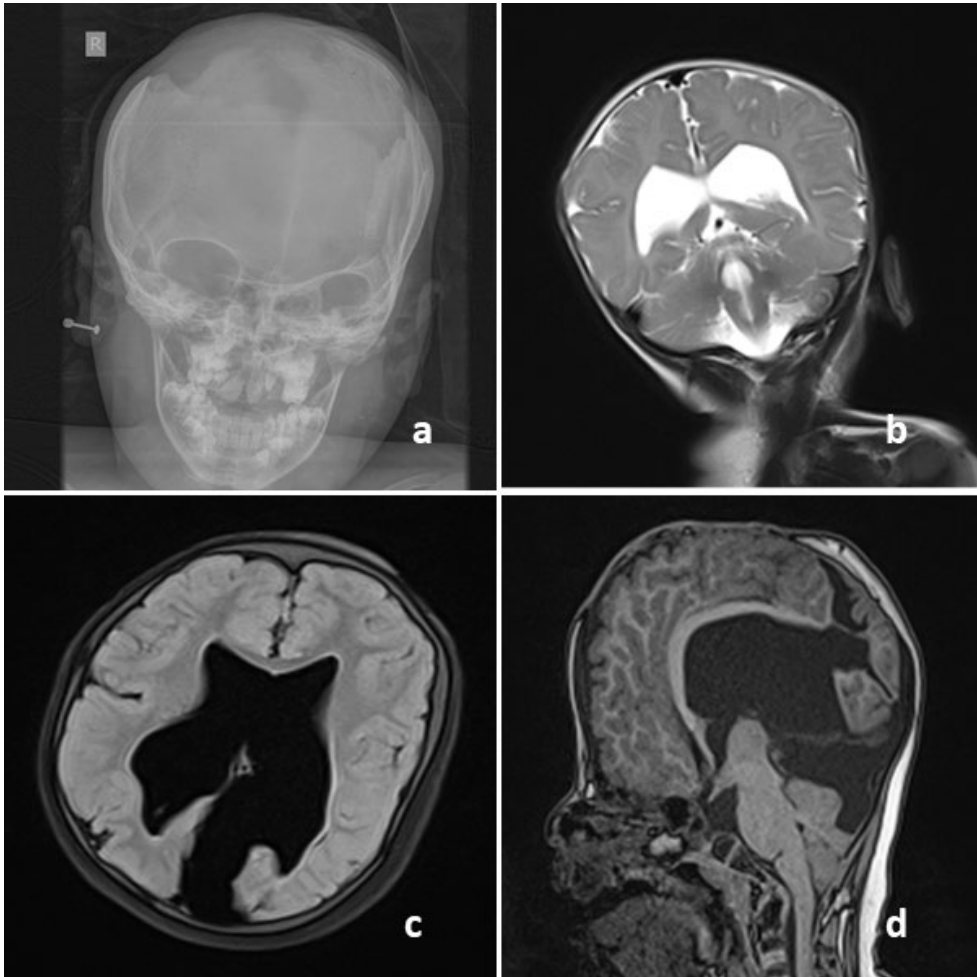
a) Acrania (skull radiograph). b) Semilobar holoprosencephaly (magnetic resonance T2 weighted coronal imaging) c,d) interrupted ventricular system with schizencephaly (magnetic resonance T1 weighted coronal and sagittal imaging).
